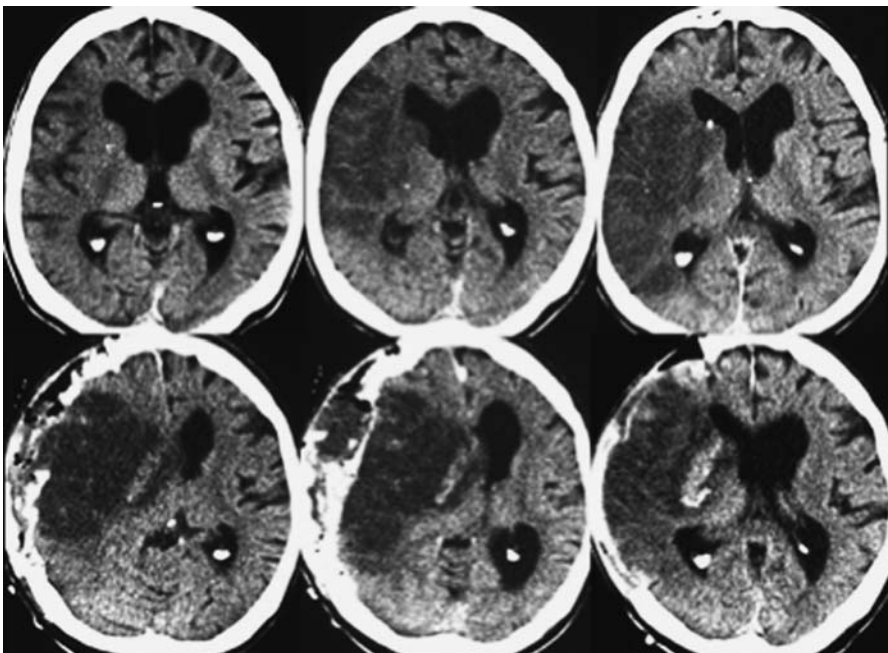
Upper row*, computed tomography of a patient with malignant right middle cerebral artery infarction on day one after onset of symptoms. *Lower row*, on day two massive edema with midline shift in spite of hemicraniectomy
